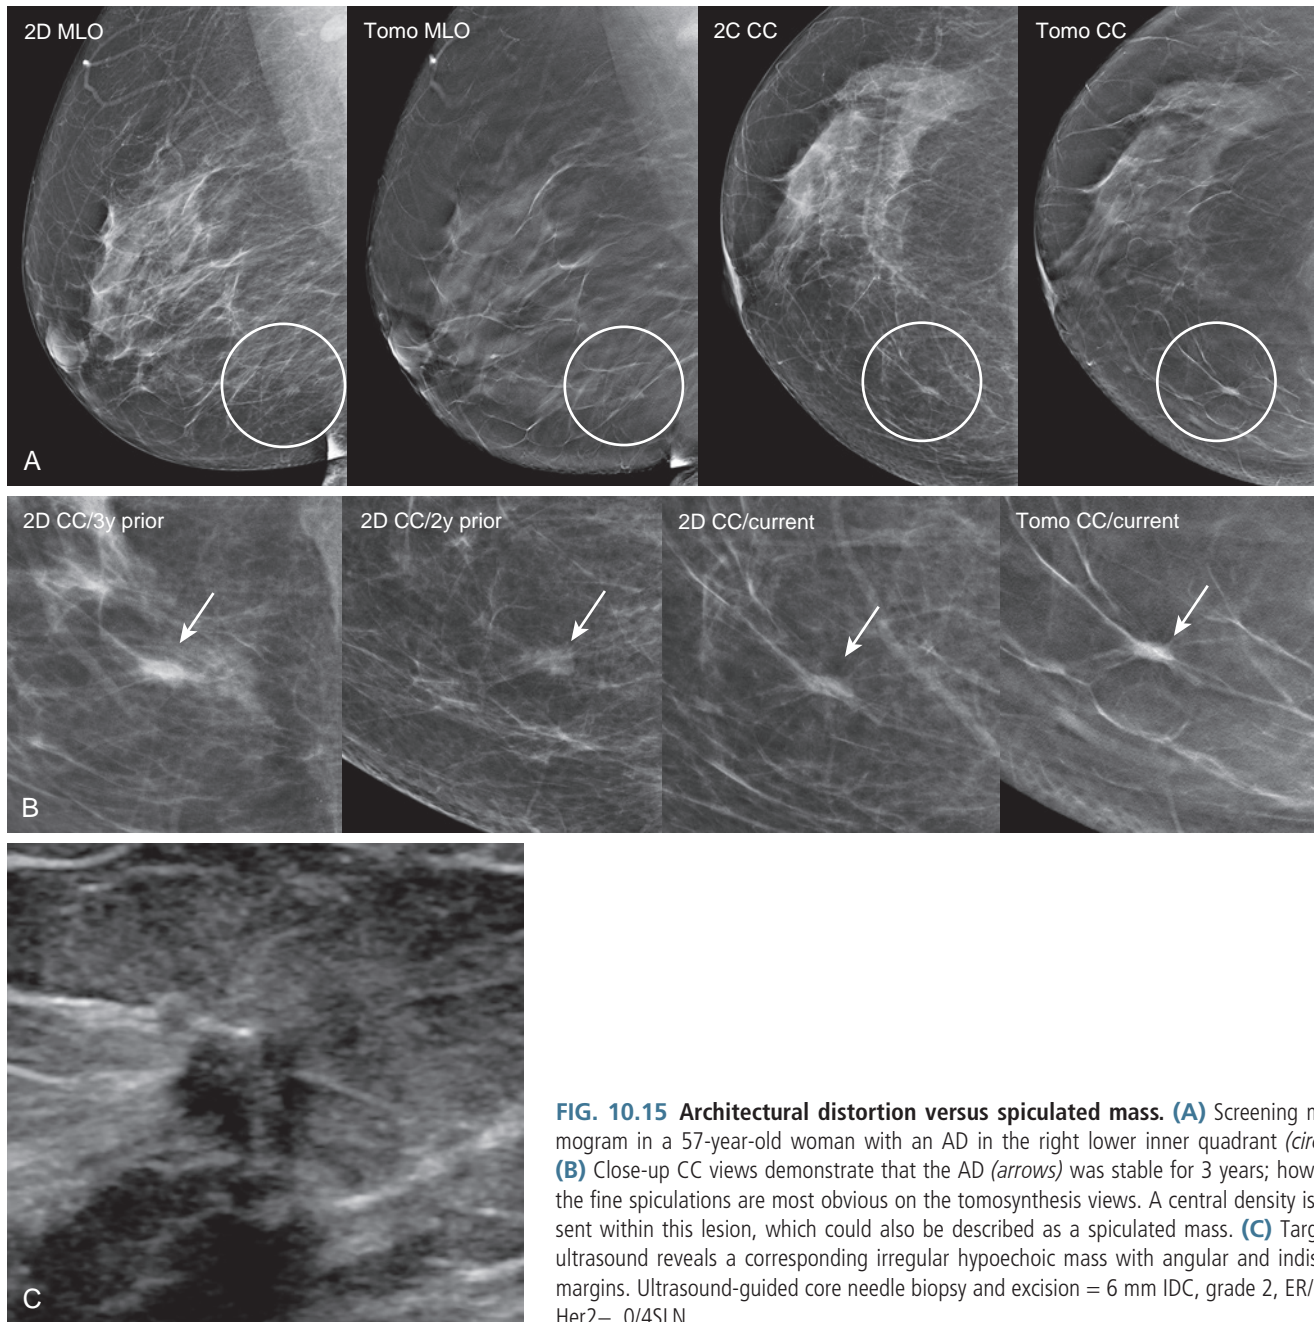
Architectural distortion versus spiculated mass. (A) Screening mammogram in a 57-year-old woman with an AD in the right lower inner quadrant (*circles*). (B) Close-up CC views demonstrate that the AD (*arrows*) was stable for 3 years; however, the fine spiculations are most obvious on the tomosynthesis views. A central density is present within this lesion, which could also be described as a spiculated mass. (C) Targeted ultrasound reveals a corresponding irregular hypoechoic mass with angular and indistinct margins. Ultrasound-guided core needle biopsy and excision = 6 mm IDC, grade 2, ER/PR+, Her2-, 0/4SLN.
